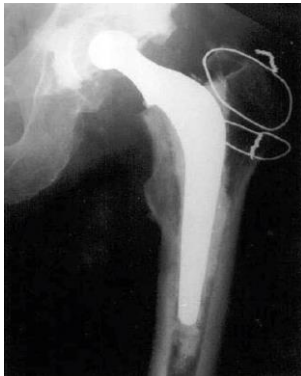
Radiograph of the Total Hip Prosthesis.
